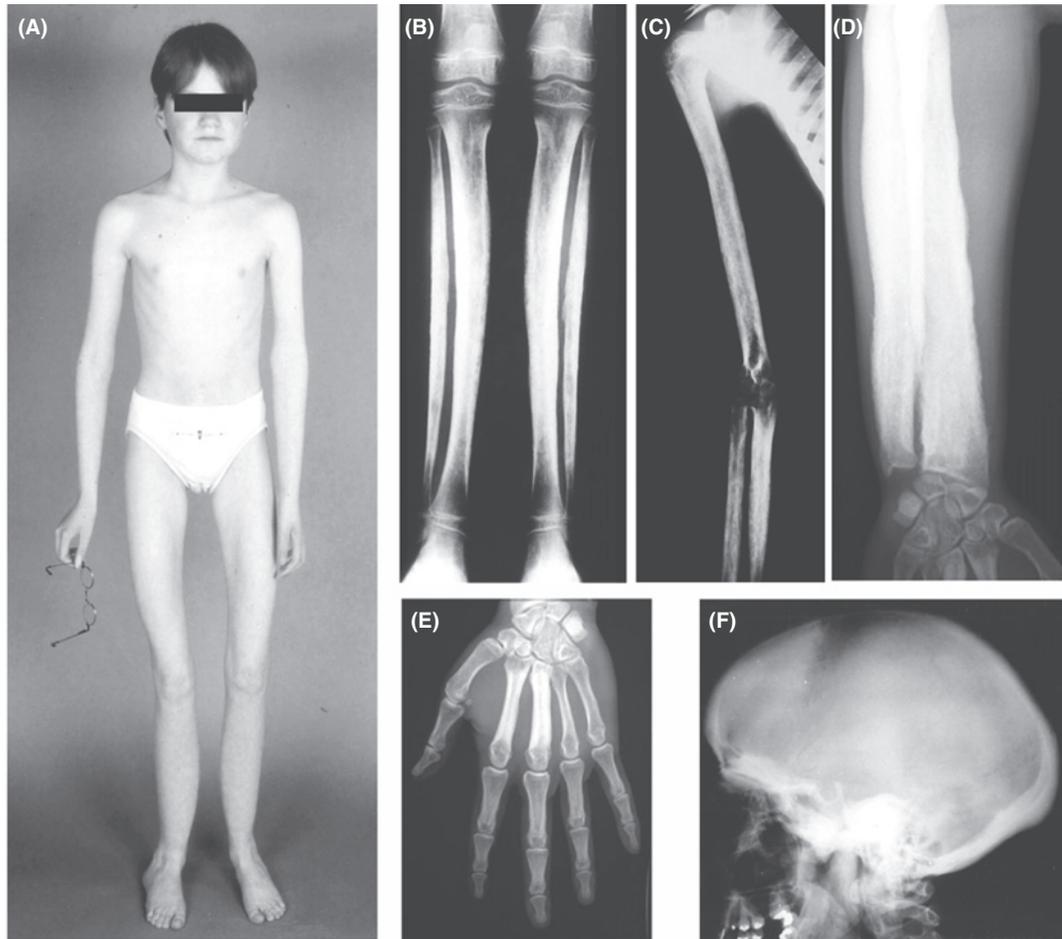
Clinical features of CED. (A) Clinical picture of a CED patient at the age of 15. Note the absence of subcutaneous fat (weight 27 kg), muscle hypotrophy, and valgus deformity of the knees and feet. Muscle weakness restricts her maximum walking distance to 20 to 50 m. Secondary sex characteristics (breast development, menstruation) were delayed. (B) AP radiographs of both lower legs of a CED patient. Note that there is cortical thickening and a severe modeling defect in the diaphyses of both tibiae and fibulae. (C) Radiograph of the right arm (AP view) of a CED patient, showing thickening of the cortex of the diaphyseal portion of the humerus, ulna, and radius, resulting in narrowing of the medullary canal. Note also the modeling defect of the long bones, which is most extensive at the diaphysis of the ulna. (D) Radiograph of the forearm of a CED patient. Marked cortical thickening at the diaphysis of the ulna and radius can be observed, causing obliteration of the medullary cavity and hypertrophy of the long bones. Note extension of the cortical sclerosis toward the distal metaphysis of the radius. (E) Radiograph of the left hand (AP view) of a CED patient, showing cortical sclerosis, cortical thickening, and medullary cavity obliteration at the diaphysis of metacarpals 2 and 3. (F) Radiograph of the skull (lateral view) of a CED patient. Sclerosis of the calvaria, the tympanic portion of the skull base, and the ascending ramus of the mandible is visible. Note relatively small frontal and sphenoidal sinuses resulting from adjacent sclerosis of the frontal bone and upper part of the face. The maxillary sinuses are spared. Images and figure legends reproduced with permission from [Janssens et al. \(2006\)](#), *Journal of Medical Genetics*, 43, 1–11.
